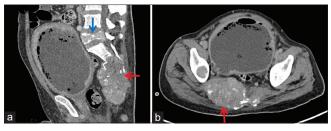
(a) Sagittal and (b) transverse sections of computed tomography abdomen showing the diffusely thickened bladder with a right-sided diverticulum and the metastatic deposits in the sacrum along with the right iliac bone (red arrow) and fifth lumbar vertebra (blue arrow)
